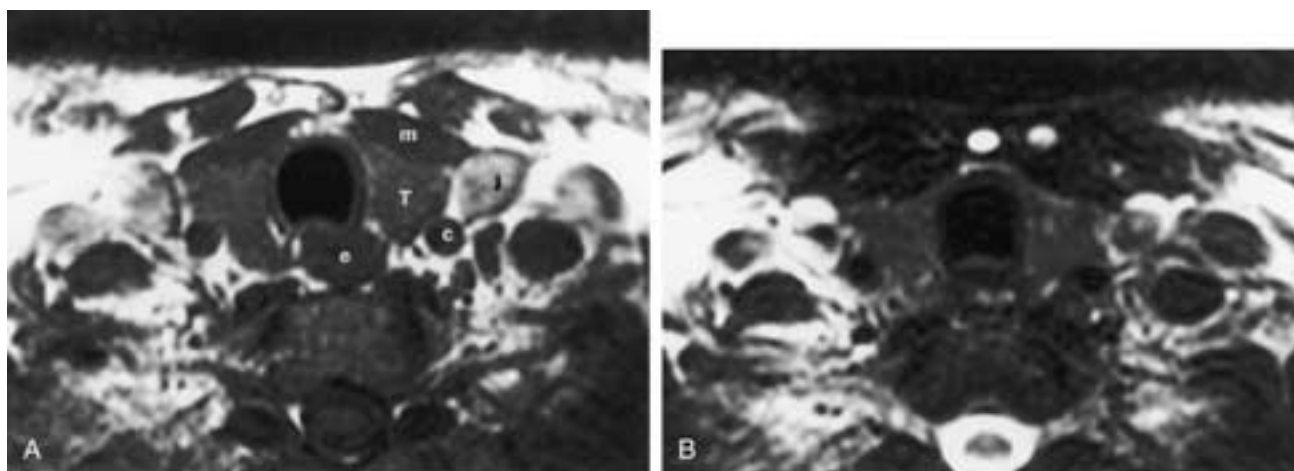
Normal thyroid gland on MR imaging. A, Unenhanced axial T1-weighted MR image shows the normal appearance of the thyroid gland (*T*), which is homogeneously hyperintense to the neck musculature (*m*). The normal anatomic relationship of the gland to the jugular vein (*J*), carotid artery (*c*), esophagus (*e*), and musculature (*m*) is shown. B, Axial T2-weighted image at the same level as A shows the normal gland to be hyperintense relative to the neck musculature.
